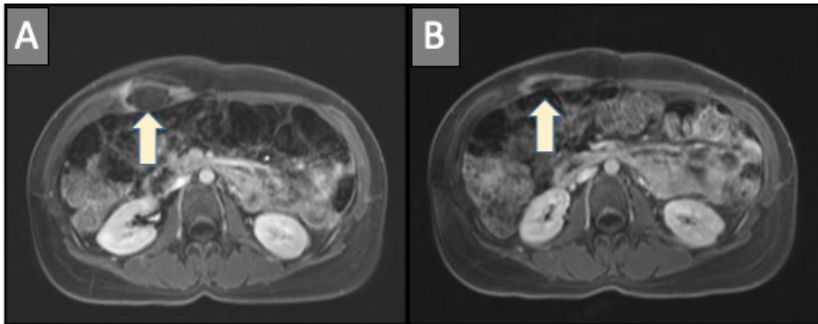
Axial delayed post contrast T1 magnetic resonance imaging images. (A) Initial imaging demonstrates peripheral enhancement consistent with post-treatment inflammation (arrow). (B) Final follow-up demonstrates decrease in tumor size and continued resolution of enhancement (arrow).
